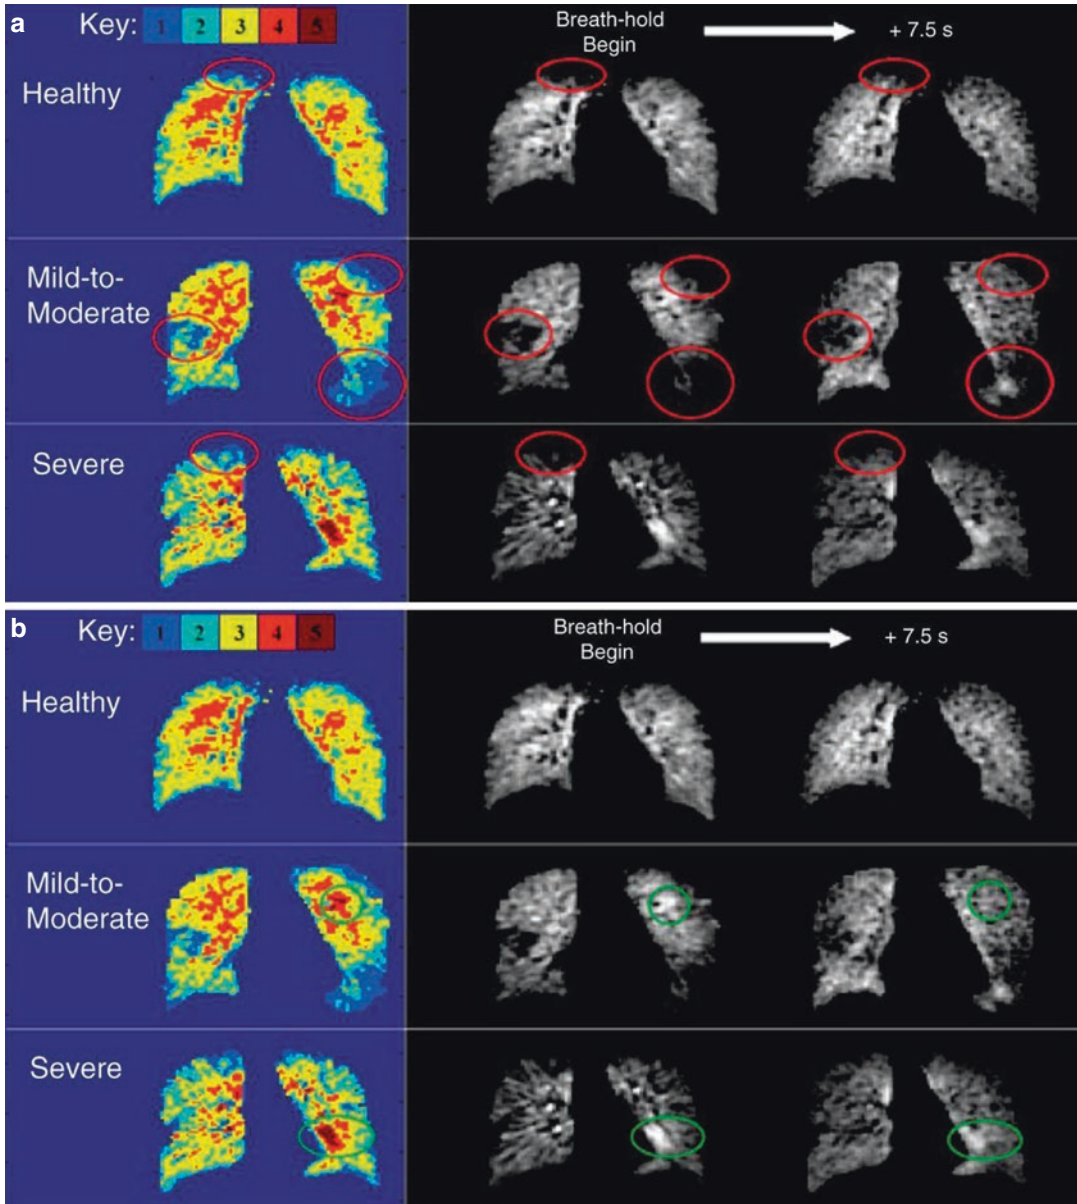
Delayed wash-in and wash-out phenomena of HP ^3He gas during fixed breath-hold MRI in healthy (female, 21-year-old), mild-to-moderate asthmatic (male, 36-year-old), and severe asthmatic (male, 45-year-old) subjects. *Color-coded maps* indicate initial ventilation classification in the displayed coronal slices. (a) Regions
